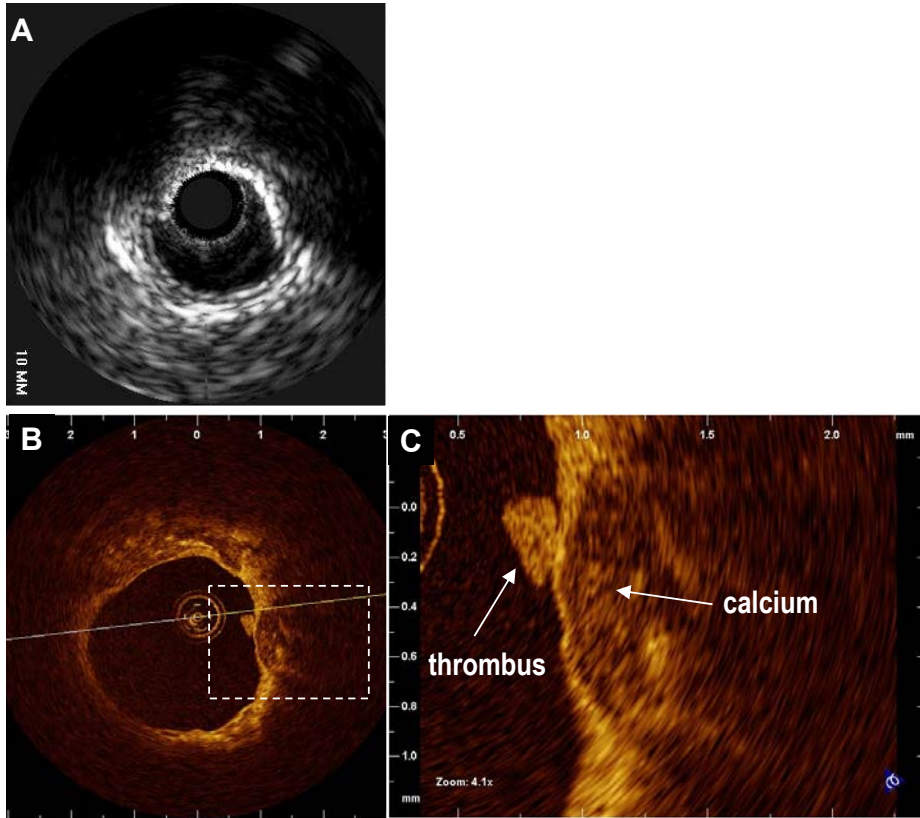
In vivo intravascular imaging of a calcified coronary plaque. A) Intravascular ultrasound shows an eccentric, calcified plaque as echodense structure with typical dorsal shadowing, while 180 degree of vessel wall show normal, three layer appearance B) Intravascular OCT of the same plaque. By OCT, calcium appears signal poor (dark) with sharp, well delineated borders. C) The magnification reveals a small mural thrombus. Note, that the calcium nodule is covered towards the lumen by a thin layer and is not in direct contact to the lumen as seen by IVUS.
